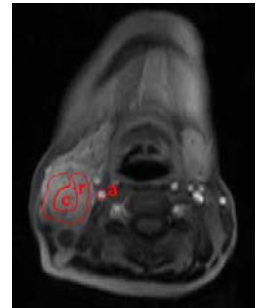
Representative ROIs shown on a T1-weighted image after CR injection.
